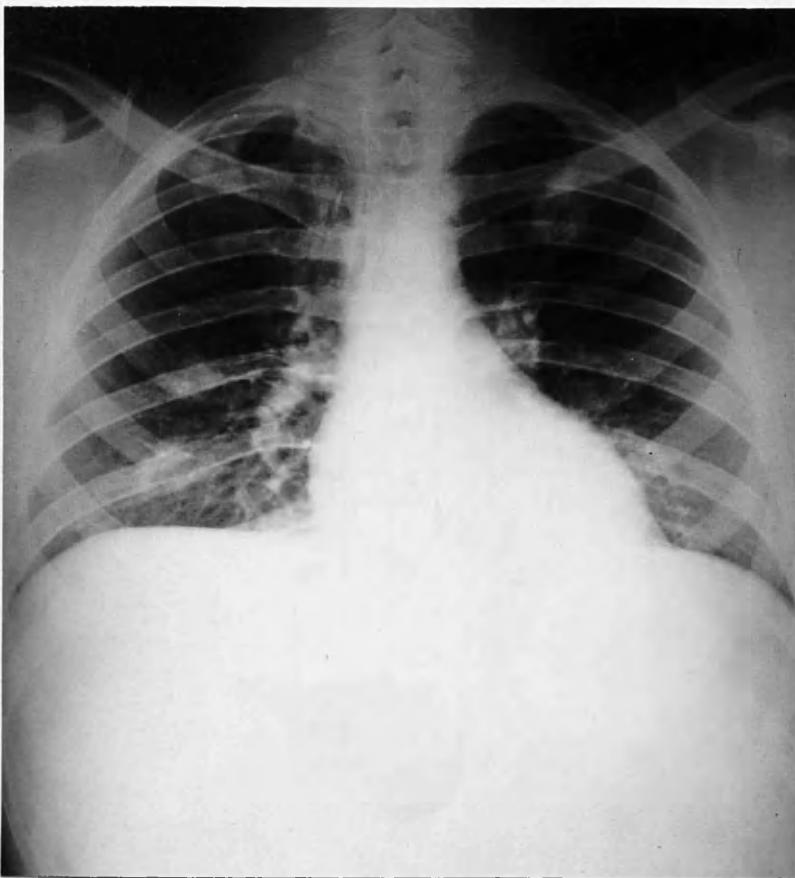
Radiograph of chest taken on 24.12.51., showing a round shadow with central translucency, behind the anterior end of the left first rib. Note the "tramlines" to the hilum and the linear shadow in the first intercostal space. The two ill-defined opacities in the right mid-zone were revealed on tomography as nodular foci also.
